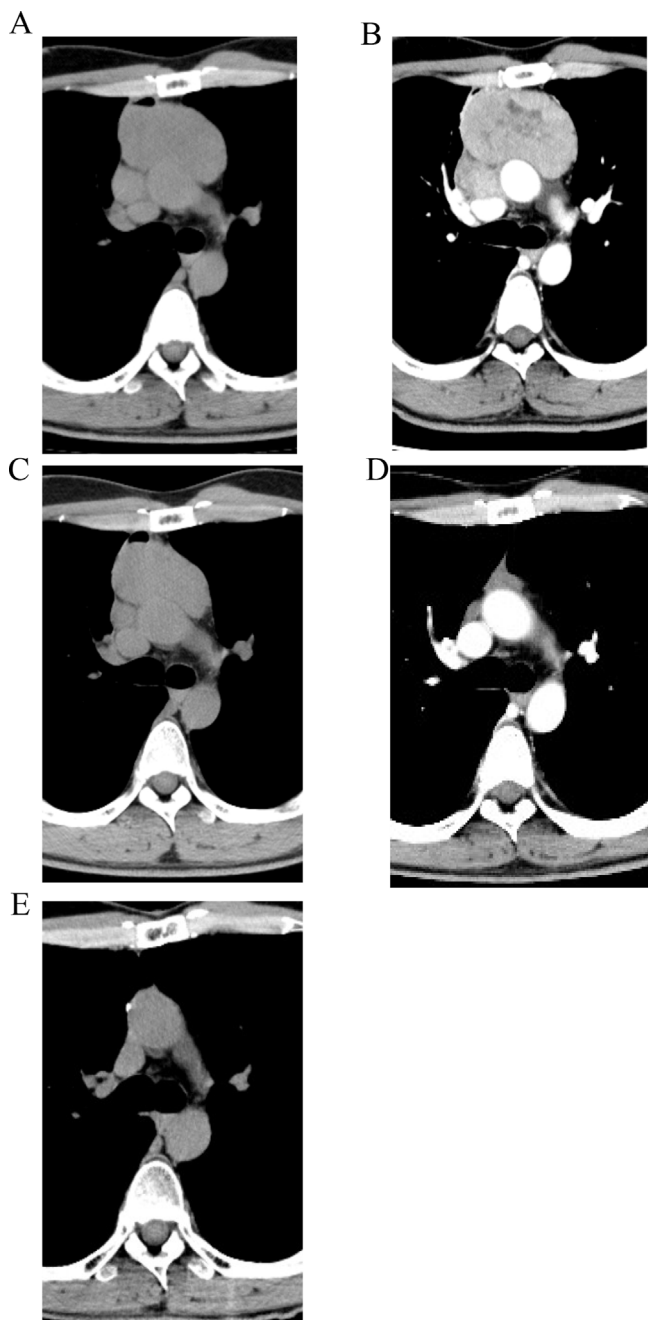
Abbreviations:  $\beta$ -hCG,  $\beta$ -human chorionic gonadotropin; CT, computed tomography; SR, spontaneous regression; IL-2R, interleukin-2 receptor; EGGCTs, extragonadal germ cell tumors.
